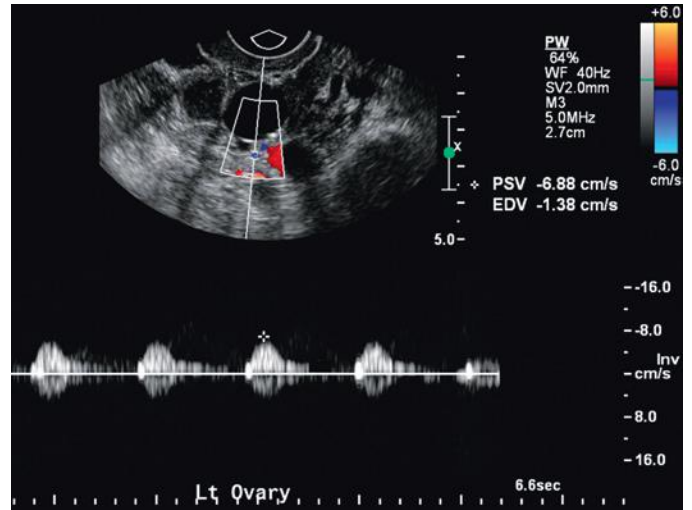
Spectral Doppler waveform of the postmenopausal ovary. Spectral Doppler tracing from the left ovary of a postmenopausal woman. Note low peak systolic velocity (PSV) and complete absence of end diastolic flow. The resistive index (RI) is 1.00.
